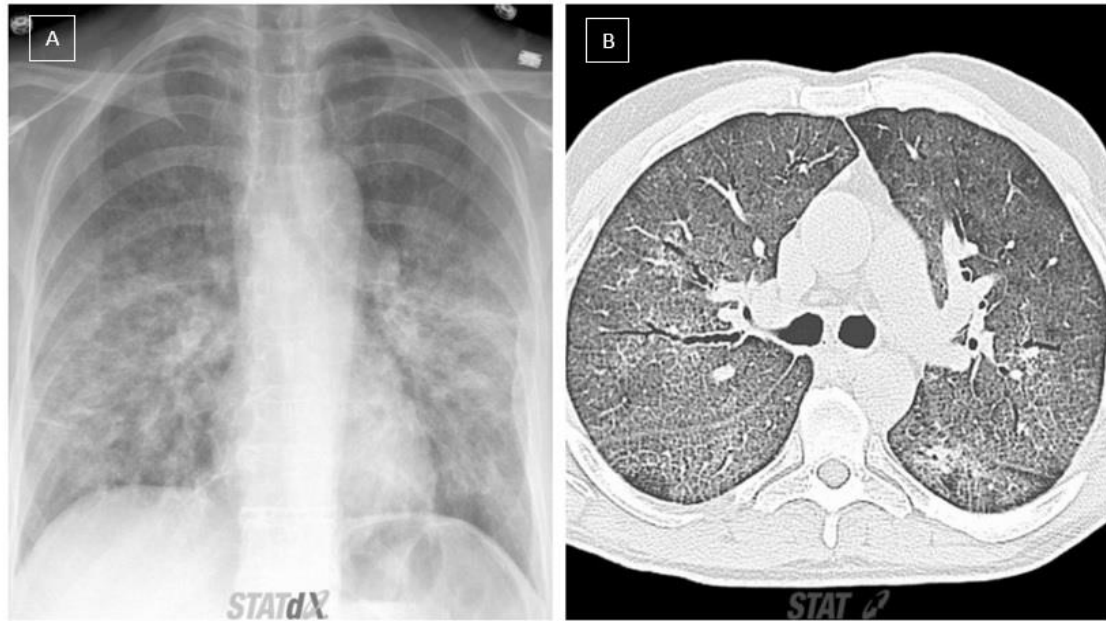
A. PA chest radiograph shows Pneumocystis pneumonia manifesting with diffuse bilateral heterogeneous opacities. B. Axial HRCT of a patient with Pneumocystis pneumonia shows diffuse bilateral ground-glass opacities on a background of reticular opacities (the so-called crazy-paving pattern).
